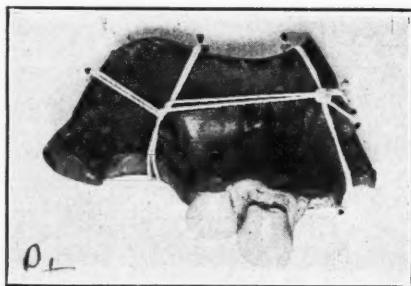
E. B. S., patient aged sixty-one years. Tooth plate. In situ thirteen hours. While eating gingersnaps, broke denture and part of it was swallowed. Diagnosis made by x-ray examination, and the foreign body was located in esophagus, opposite seventh cervical vertebrae. Symptom was that patient could not swallow solids. Removed by esophagoscopy, under local anesthesia. Results: Patient cured.
